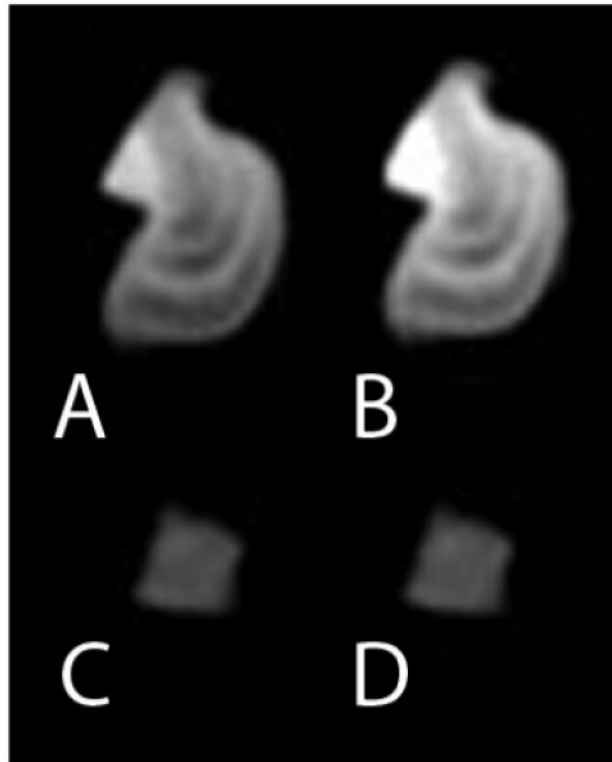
Renal stones imaged at DECT. A 140 kVp CT image of a struvite stone(A) shows much lower attenuation than the 80 kVp image (B). In contrast, the uric acid stone shows a relatively unchanged attenuation when imaged at 140 kVp (C) and 80 kVp (D). This basic principle can be exploited to semiautomatically classify renal stones as uric acid or non-uric acid composition and aid in patient triage.
